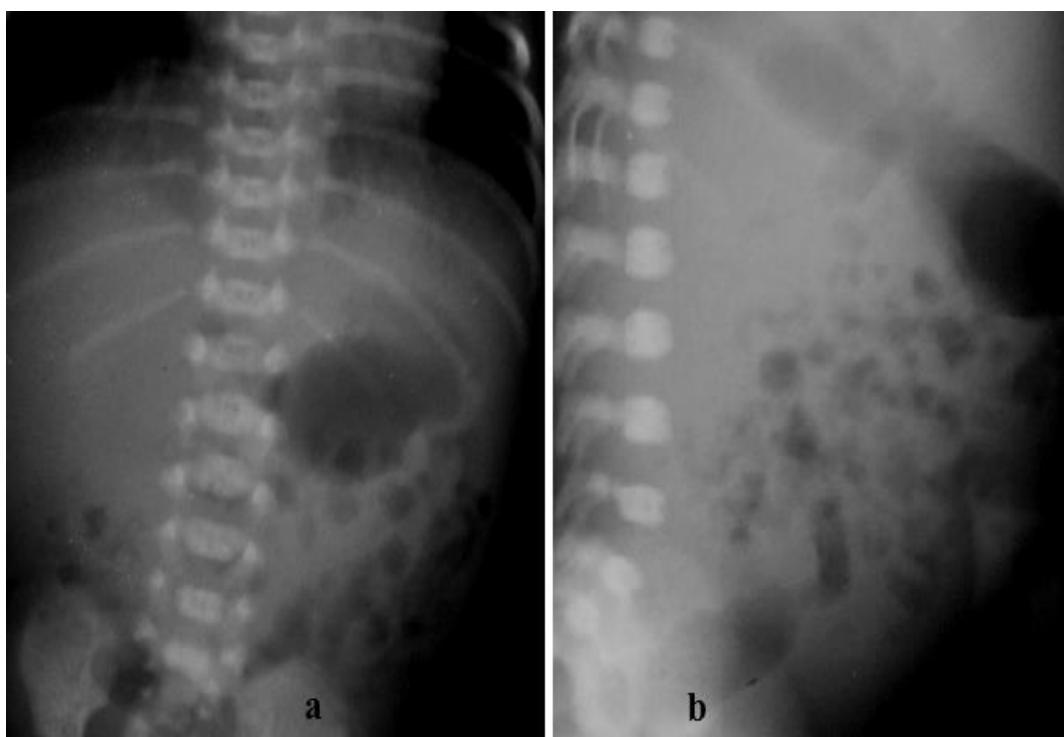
Plain abdominal radiograph showing blobby, soap bubble and foamy appearance in the abdomen due to necrotising enterocolitis (a and b).
